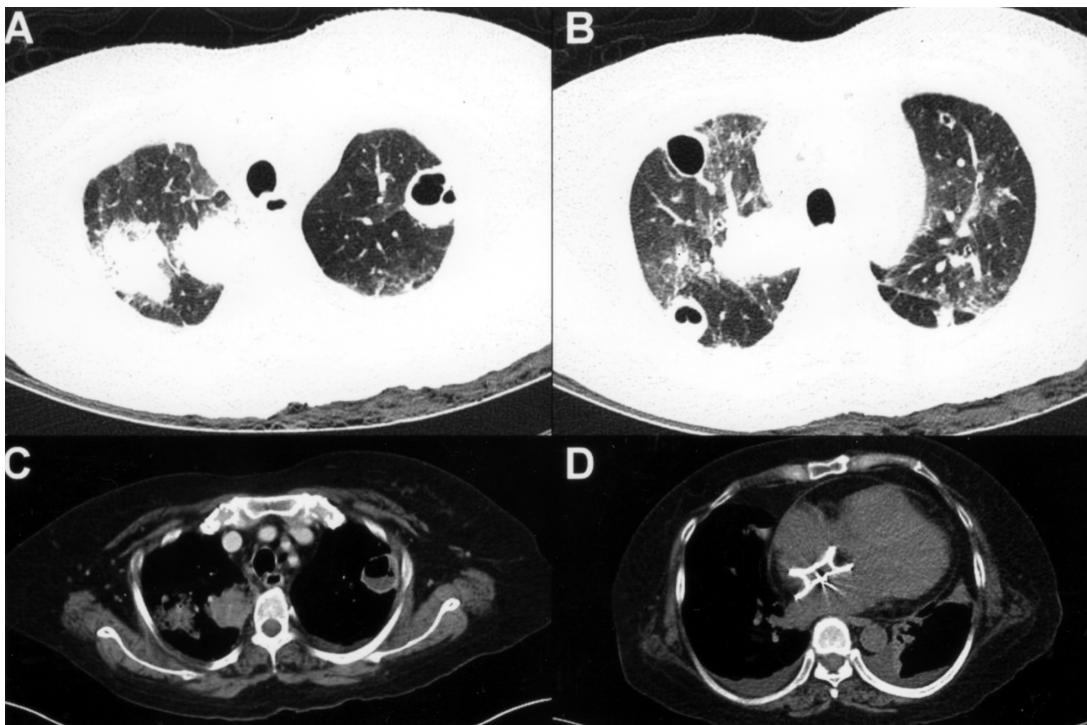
Chest CT scan. (A,B) Lung window setting: multiple consolidative lesions, and infiltrates with cavitation in the bilateral lung fields; (C) Mediastinal window setting: air-fluid levels in the cavities indicating lung abscess formation; (D) Interatrial obstructor: An obstructive device in the interatrial septal area.
